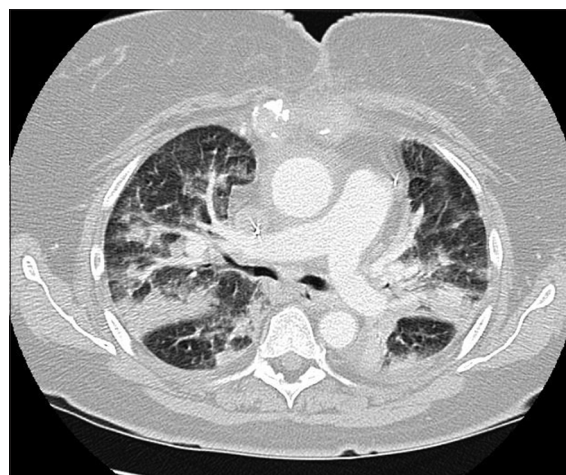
Computed tomography of the chest on admission showed bilateral diffuse extensive pulmonary infiltrates and consolidations without evidence of pulmonary embolism
